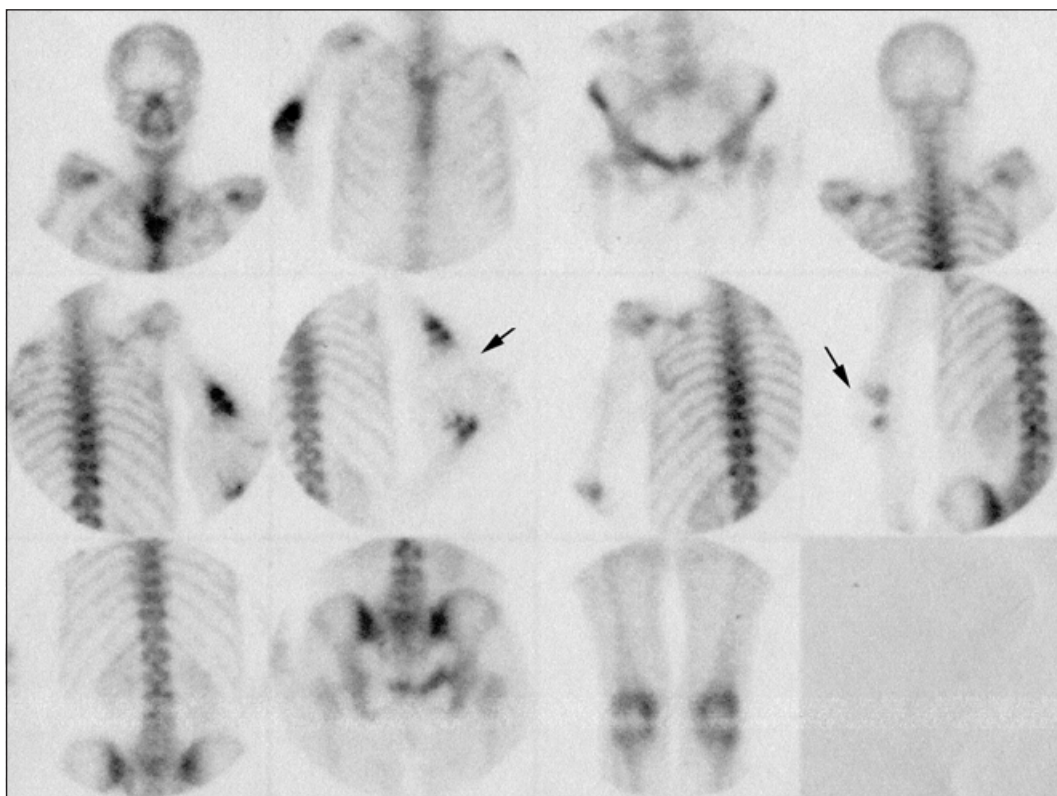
Bone scan obtained 2.5h after the administration of 555MBq of ^{99m}Tc -MDP to the patient. The arrows indicate the presence of the lytic lesions initially seen in the CT scan.
